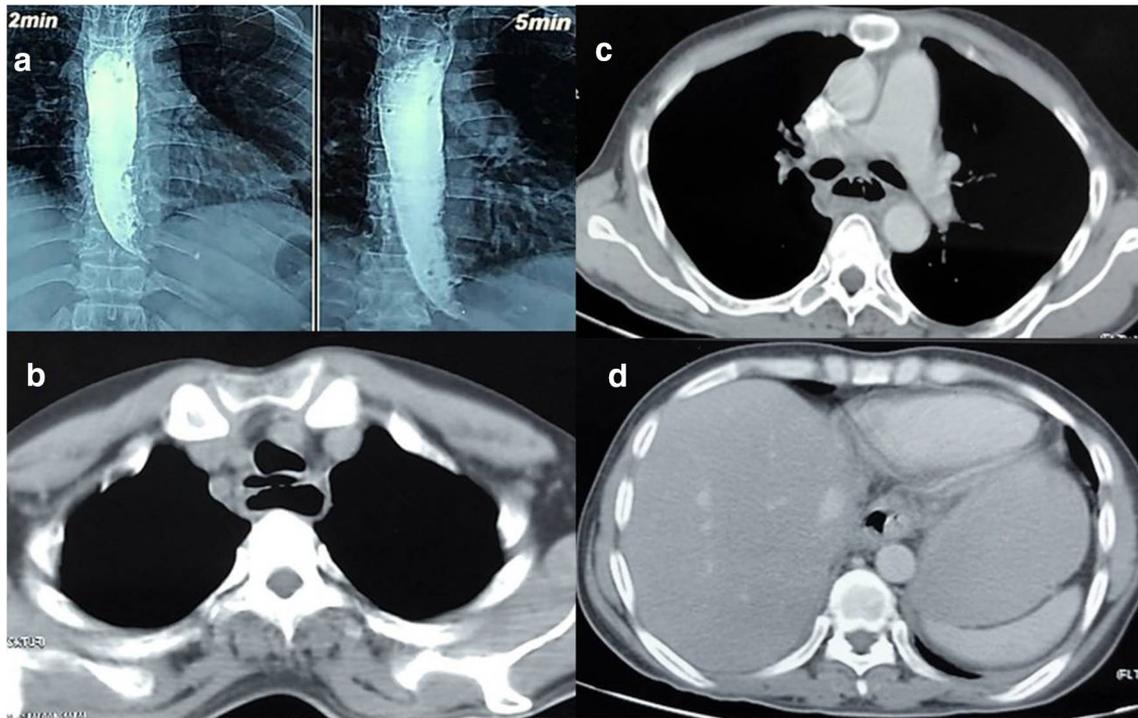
(a) Barium swallow picture showing entry of contrast into cul de sac and retention at GEJ. b, c, d) Contrast-enhanced computed tomogram from upper esophagus to GEJ level showing double barrel appearance consistent with IED
